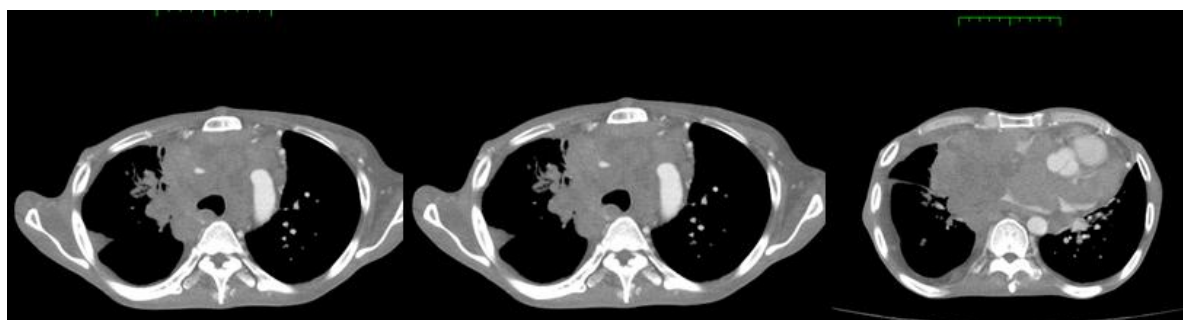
Contrast-enhanced chest CT scan of a patient with mediastinal NEC, showing a large right-sided mediastinal mass, extended to the right hemi-diaphragm with the encasement of SVC
